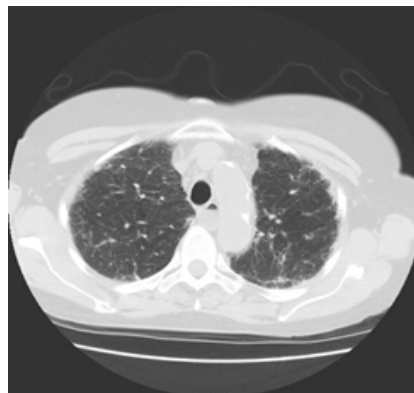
HRCT chest showed few linear subpleural parenchymal opacities right lower lobe without honeycombing
